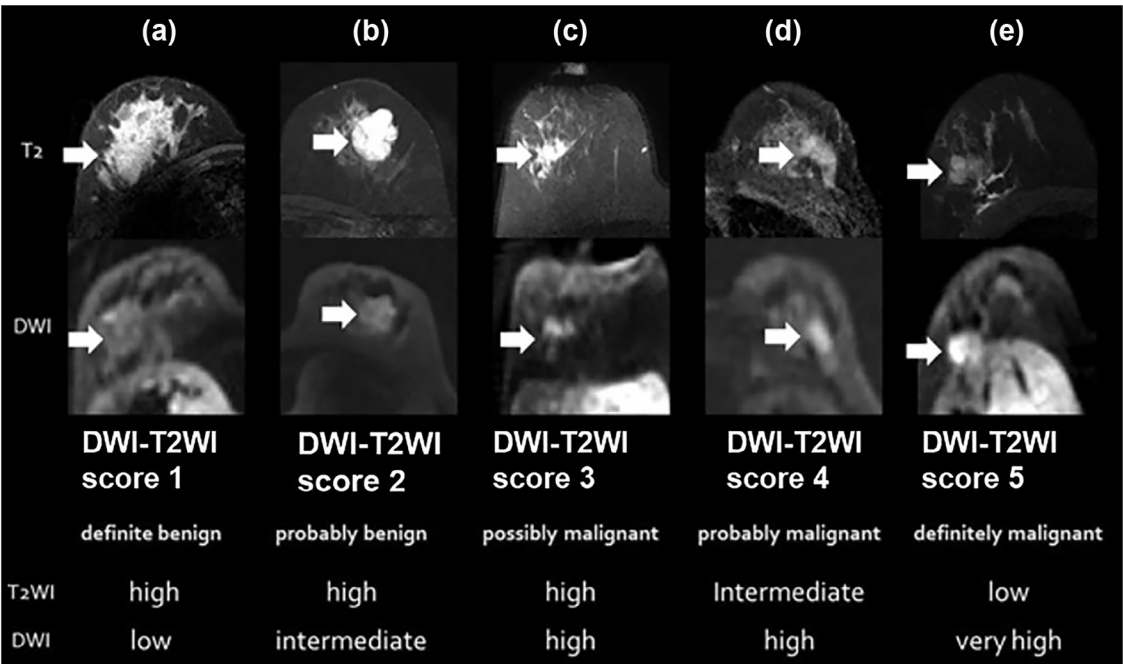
Examples of breast lesions for reader diffusion-weighted imaging and T2-weighted imaging (DWI-T2WI) scores used for lesion characterization. (a) DWI-T2WI score 1 (definitely benign) showed high signal intensity (SI) on T2WI and low SI on DWI; (b) DWI-T2WI score 2 (probably benign) showed high SI on T2WI and intermediate SI on DWI; (c) DWI-T2WI score 3 (possibly malignant) showed high SI on T2WI and high SI on DWI; (d) DWI-T2WI score 4 (probably malignant) showed intermediate SI on T2WI and high SI on DWI; and (e) DWI-T2WI score 5 (definitely malignant) showed low SI on T2WI and very high SI on DWI.
